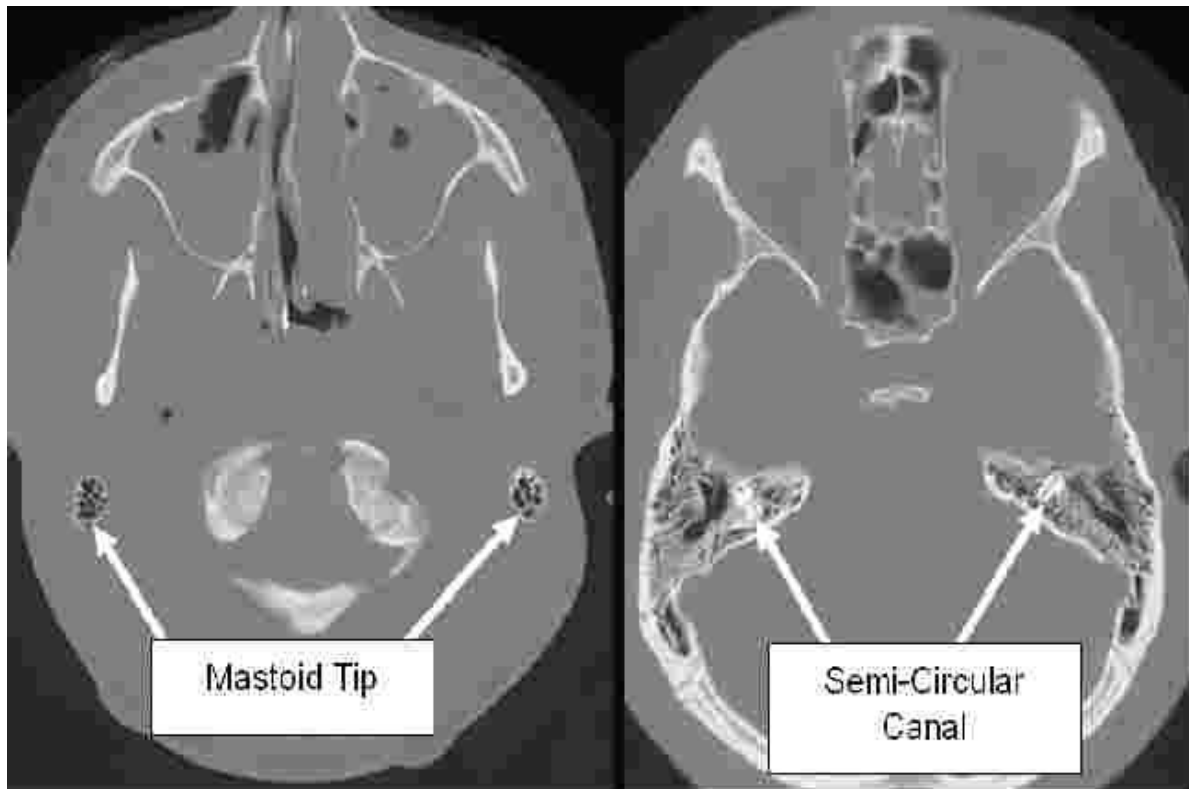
Axial images Temporal Bone CT(Gentry.Ranallo, 2009)
